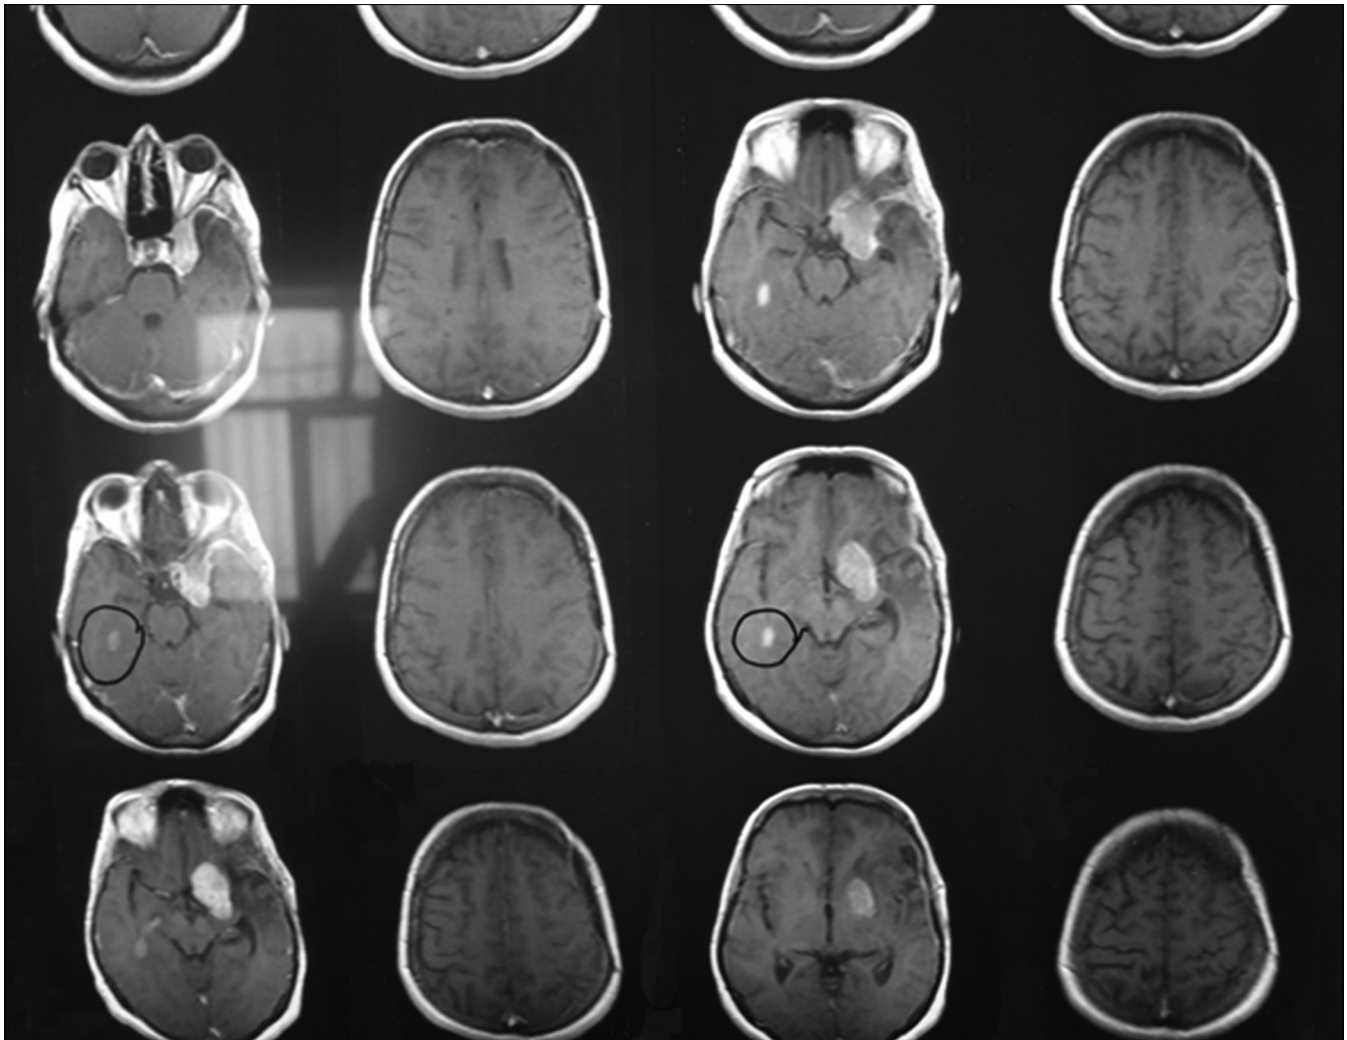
Multiple lesions in periventricular, centrum semiovale and corpus callosum in magnetic resonance imaging of the patient
